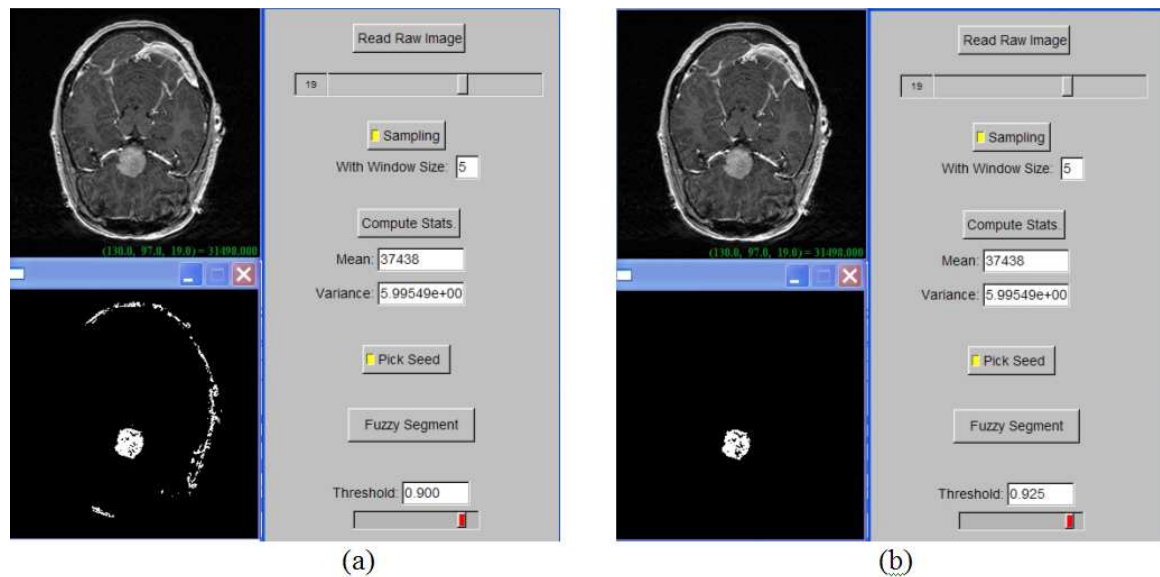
Fuzzy segmentation of a brain tumor from a patient MRI data, with FC threshold (a) 0.9, and (b) 0.925.
